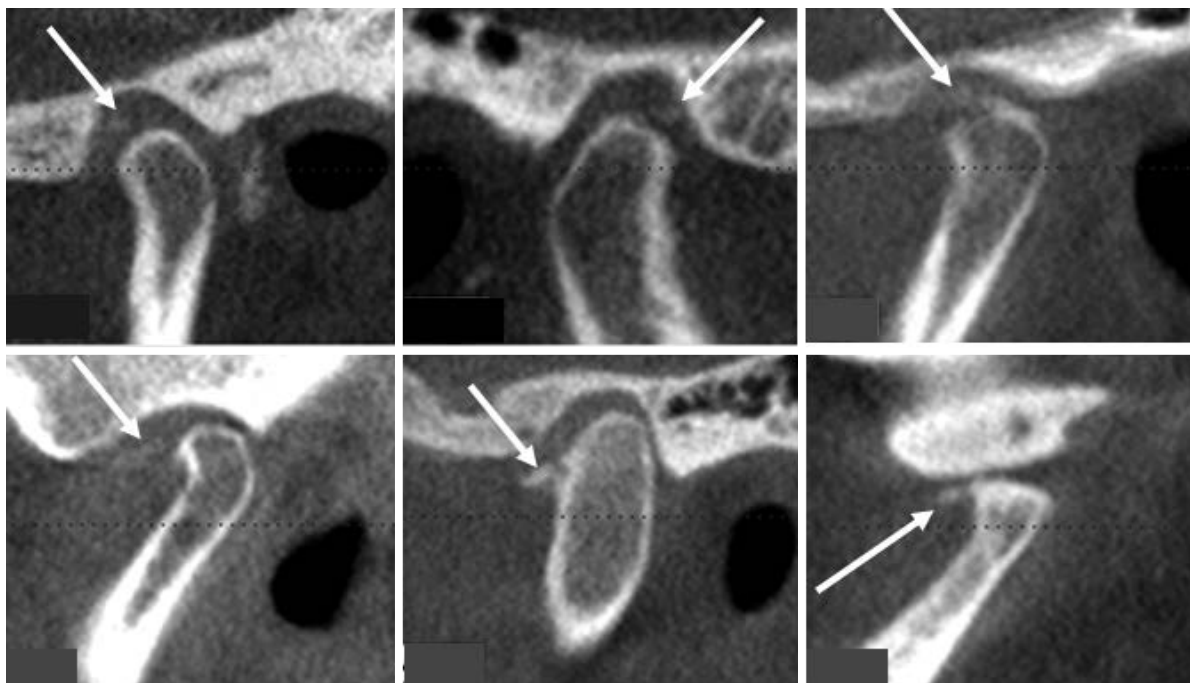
Sagittal reconstructed cone-beam computed tomographic images show calcification of the temporomandibular joint (white arrows).
